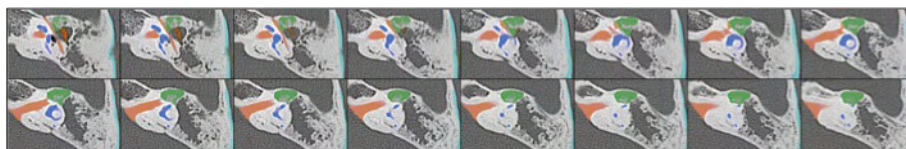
Colored CT images of case 1; left ear. The cholesteatoma of petrous bone part is colored in green.
